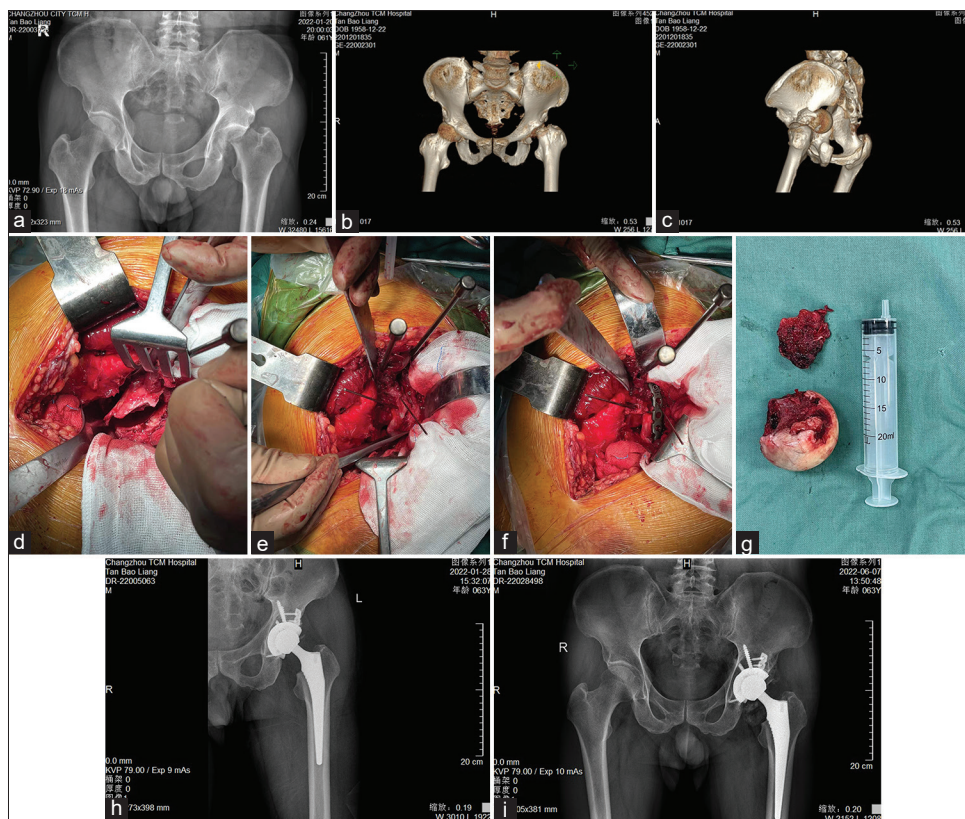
A 63-year-old male cyclist had an injury to his left hip following a traffic accident. (a-c) The AP film and 3D reconstructed CT of the pelvis preoperatively revealed the presence of a displaced fracture of the posterior column, ipsilateral femoral neck fracture combined with posterior traumatic hip dislocation, (d) Intraoperative photos showed the existence of displaced fracture of the posterior column, (e) Temporary fixation of the posterior column, (f) Final fixation of the posterior column with locking plate, (g) The femoral head showed severe chondral defect and bone compression, (h) Postoperative plain film showed a well reduction and prosthesis position, (i) The latest follow-up plain film showed a well-seated prosthesis position with no evidence of subsidence. 3D: Three-dimensional, CT: Computed tomography
